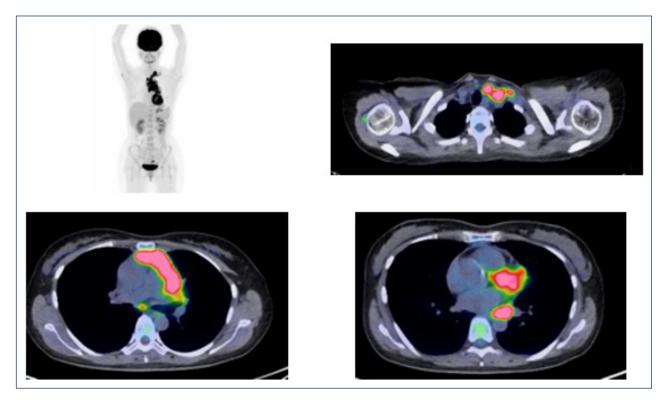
PET-CT before treatment. The scan showed abnormal accumulation in the mediastinal mass.
